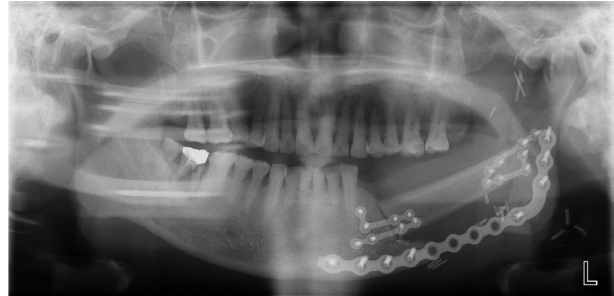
Postoperative panoramic radiograph showing fibular flap reconstruction in the alveolar part.
